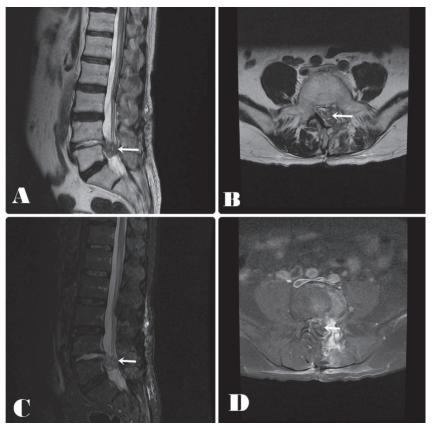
MRI scans showing contrast enhanced mass MRI: Magnetic resonance imaging
